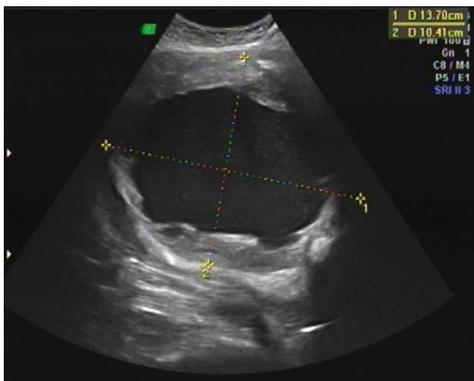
Transabdominal ultrasound showing fibroid with cystic degeneration.
